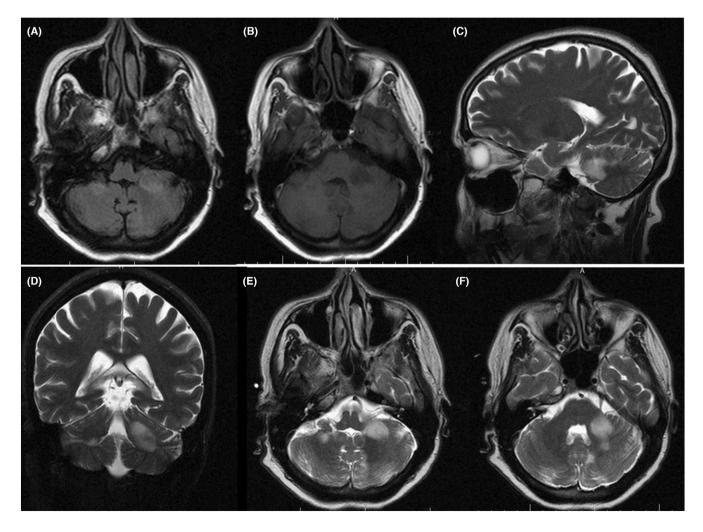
Brain MRI axial FLAIR image showing hyperintense bilateral MCP lesion (A), hypointense MCP lesion in axial T1 weighted (B), sagittal, coronal, and axial T2 weighted showing hyperintense MCP lesions (C–F).
